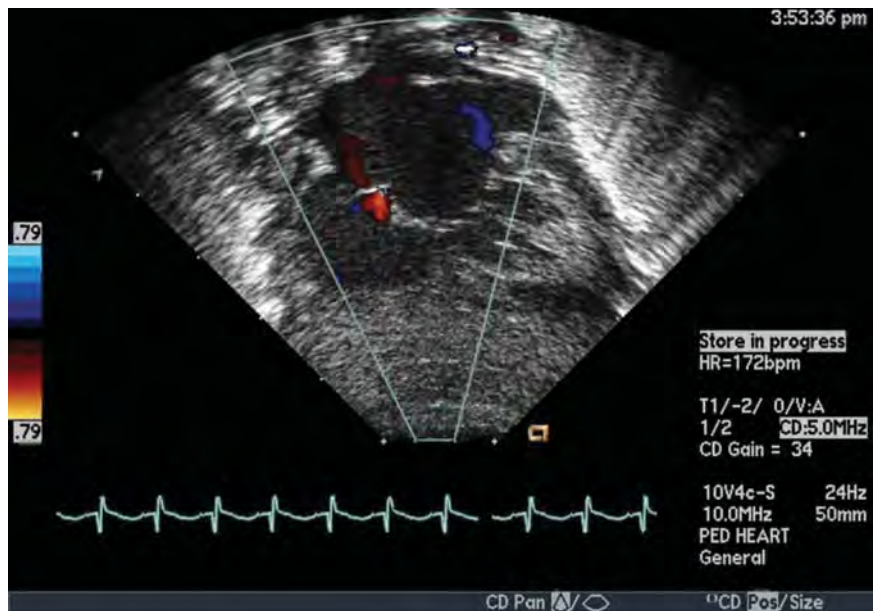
Color Doppler parasternal short axis view of a patent ductus arteriosus (PDA).
